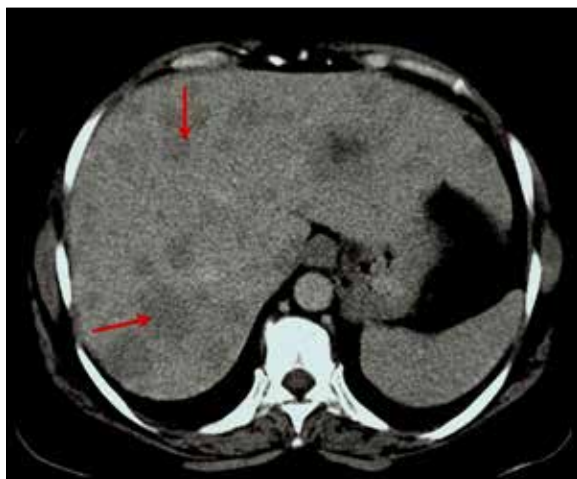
Contrast-enhanced CT scan of the upper abdomen shows multiple non-enhancing metastases (red arrows).
